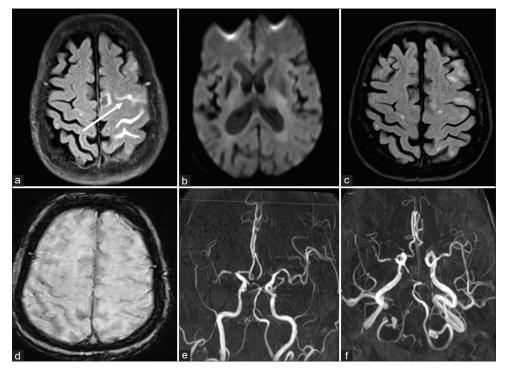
Case 2. Immediate post-thrombectomy MRI shows hyperintense signal along the left superior frontal sulci on axial FLAIR images (White arrow, a). No new infarcts or hemorrgae is seen on Diffusion weighted image (b). Subsequent MRI done 26 hours after the endovascular intervention revealed resolution of the sulcal FLAIR hyperintensities along the left frontal sulci (c). No evidence of hemorrhage was noted on axial Susceptibility weighted image (d). Time-of-flight MR angiogram (e, f) shows patency of the left ICA and left MCA
